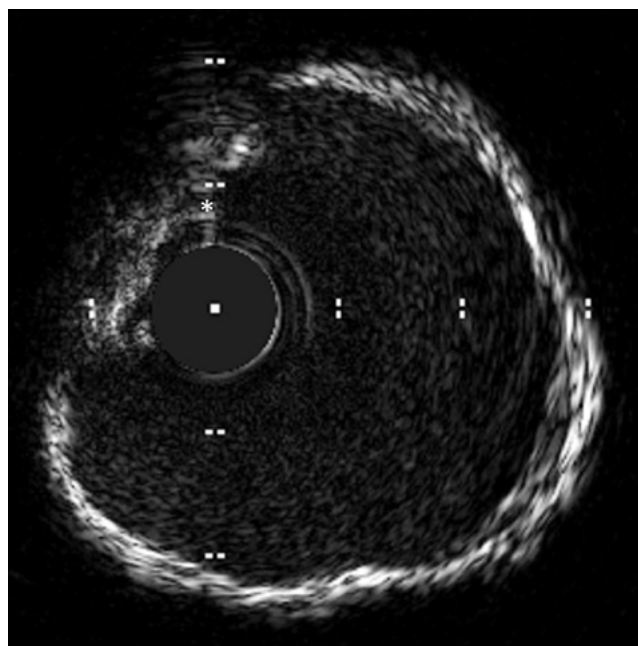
Superficial, 360° calcification, wire artifact (white asterisk) – intravascular ultrasound
